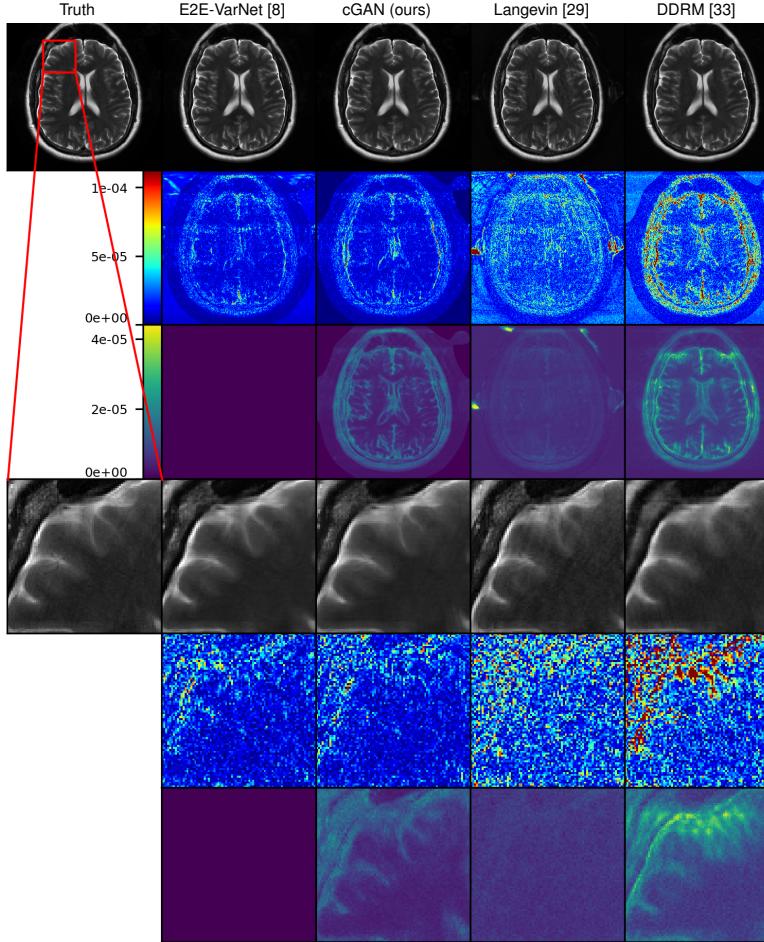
Example $R = 4$ MRI reconstructions with $P = 4$. Rows 1 and 4: P -sample average $\hat{x}_{(P)}$. Rows 2 and 5: pixel-wise absolute error $|\hat{x}_{(P)} - x|$. Rows 3 and 6: pixel-wise SD $(\frac{1}{P} \sum_{i=1}^P (\hat{x}_i - \hat{x}_{(P)})^2)^{1/2}$. Rows 4 through 6 show a zoomed region.
